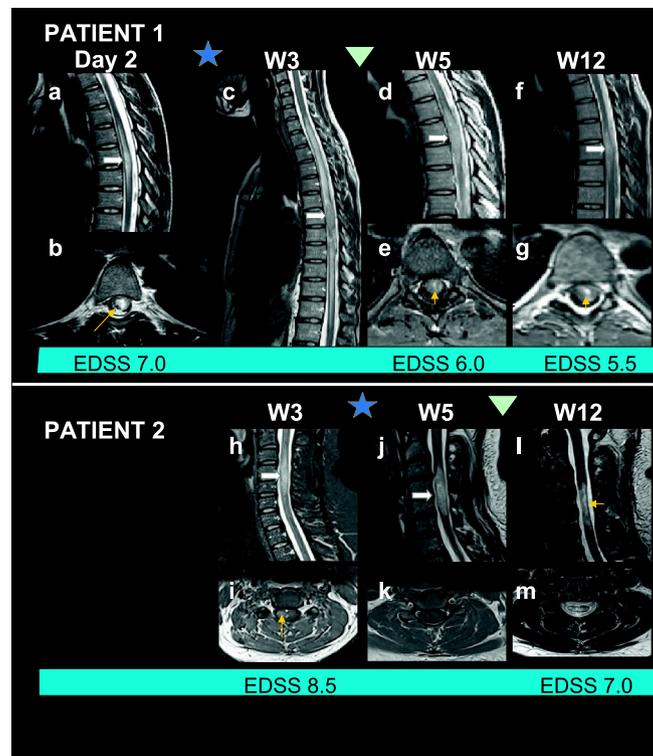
Longitudinal spinal cord MRI follow-up in patient 1 (a-g) and patient 2 (h-m).
